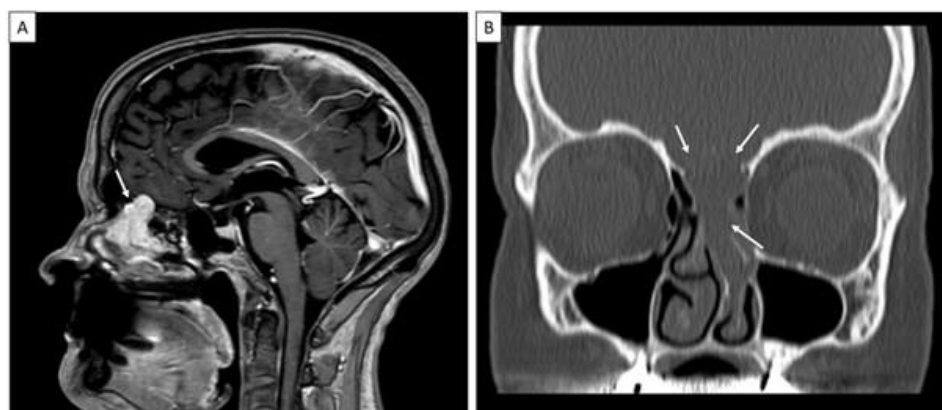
(A) Sagittal T1-weighted contrast-enhanced MRI demonstrating a well-circumscribed frontobasal lesion with predominantly homogeneous enhancement, contacting the inferior frontal lobe and extending into the nasal cavity. (B) Coronal MRI view of the centropfacial region revealing partial destruction of adjacent bony structures, including erosion of the central skull base and superior nasal septum. Arrows indicate tumor borders.
